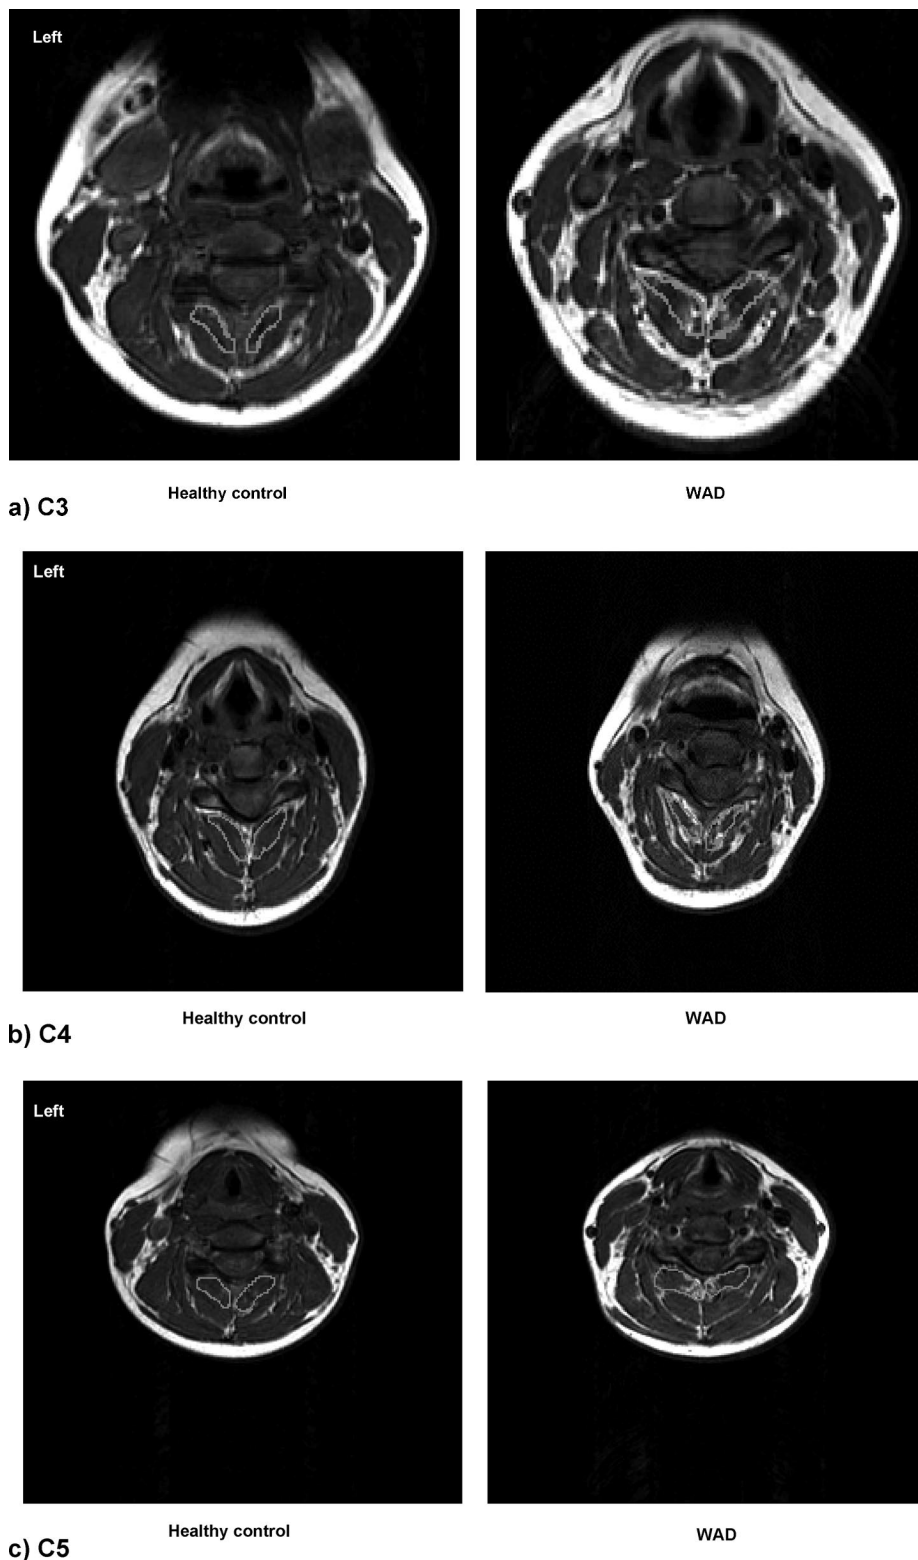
a–e, Bilateral axial MR images of the segmental cervical multifidus muscles, C3–C7 (healthy control vs. WAD subjects).
